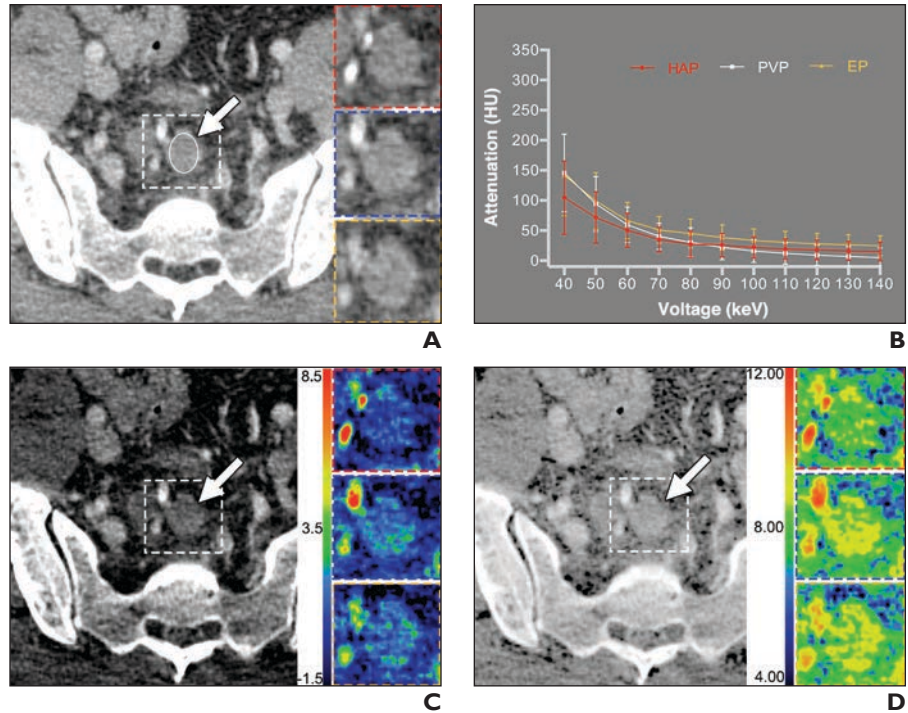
42-year-old man with poorly differentiated pathologic T3N2 rectal adenocarcinoma. Representative dual-energy CT examination of metastatic lymph node. Dashed line indicates location of inserts. Inserts show hepatic arterial phase (red), portal venous phase (blue), and equilibrium phase (yellow) images.
